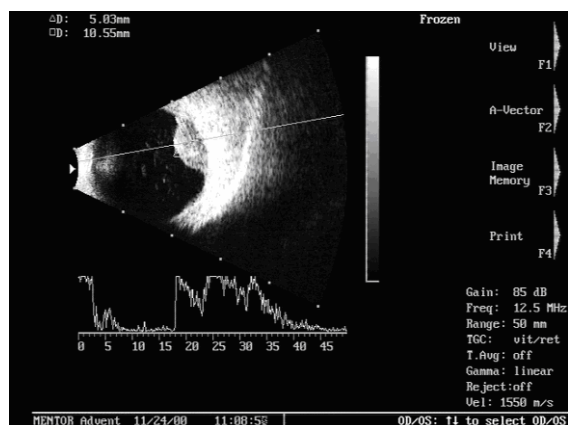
Typical image, obtained with the ultrasound research MENTOR Advent A/B System
